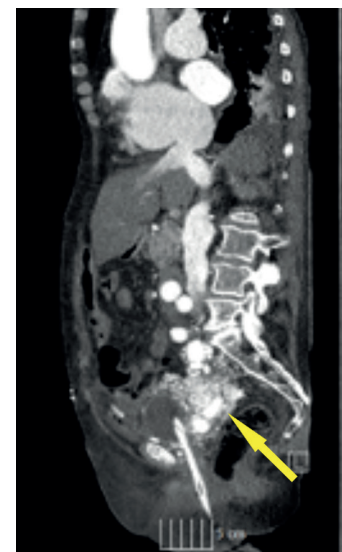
Computed tomography angiogram in sagittal plane showing arteriovenous malformation.
